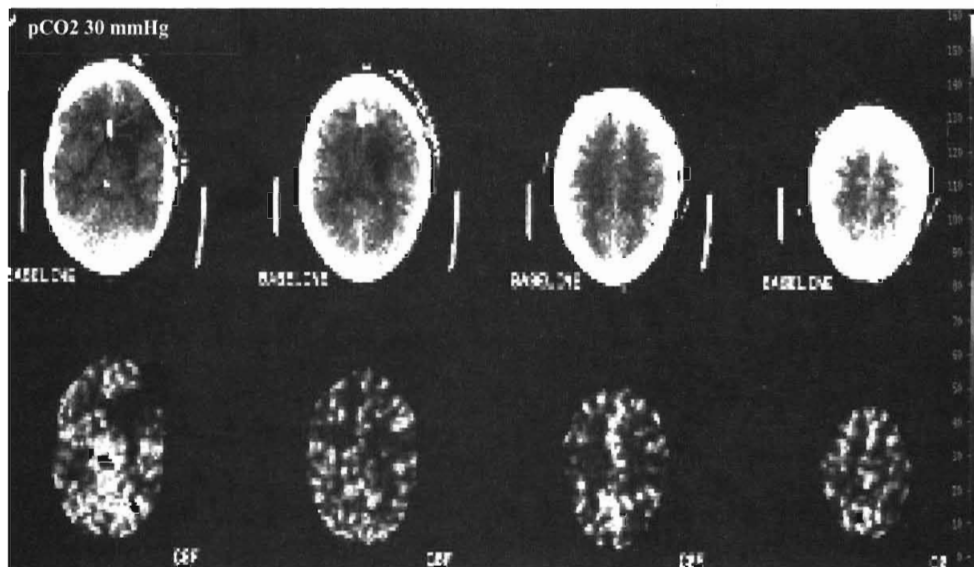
Computed tomography scans of a head-injury patient with an intracranial pressure (ICP) of 70 mm Hg and P_{aCO_2} of 30 mm Hg but diffusely normal to hyperemic cerebral blood flows. (See color section in this text.) (Courtesy of Howard Yonas, University of Pittsburgh.)
